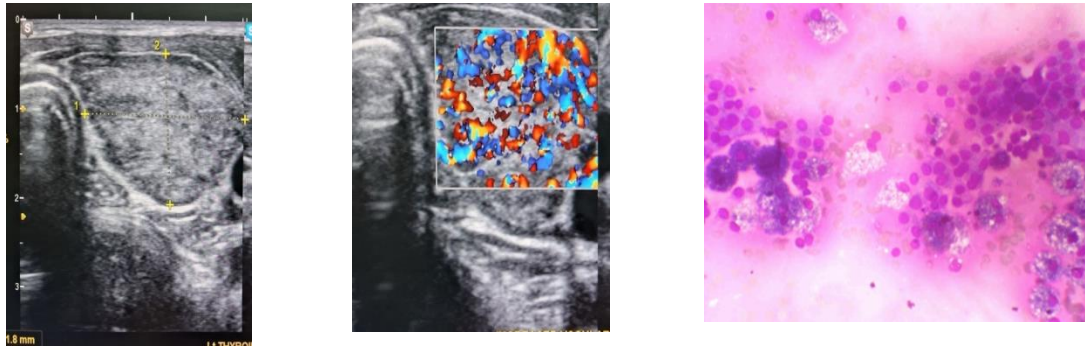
Multi nodular goitre:40-year-old female with swelling in midline of neck. On USG, B/L lobes of thyroid had multiple, <5mm in size, smooth marginated, heterogeneously hypoechoic nodules.The gland showed diffusely increased vascularity on colour doppler study.Thyroid FNAC of the gland shows follicular epithelial cells with foamy macrophages on the background of diffuse goitre.
